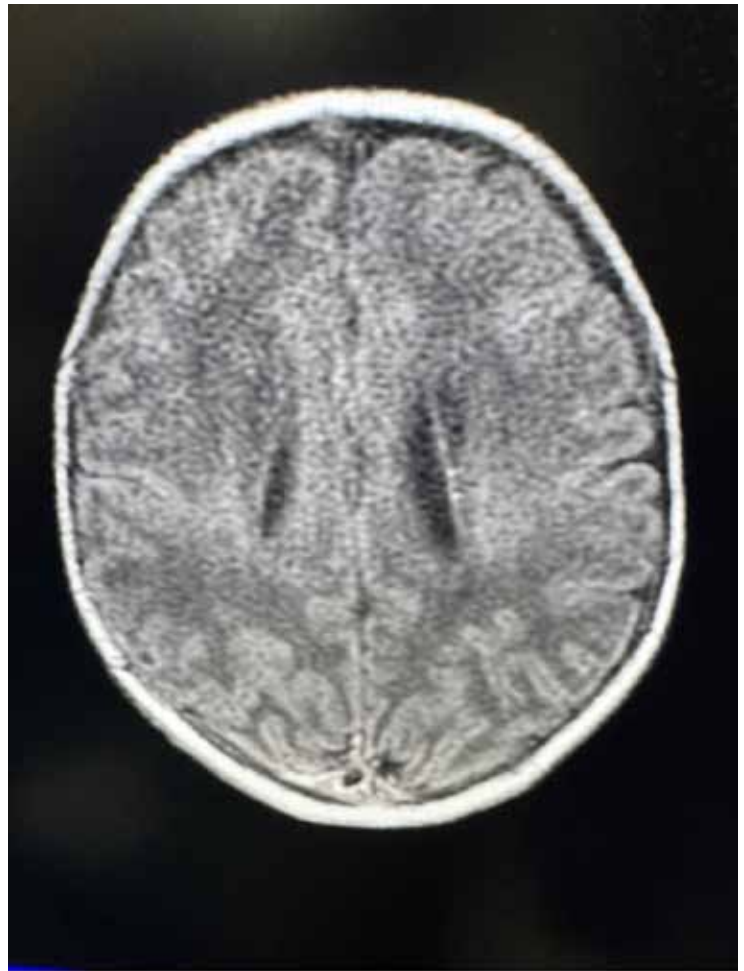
MRI brain showing cystic encephalomalacia.
